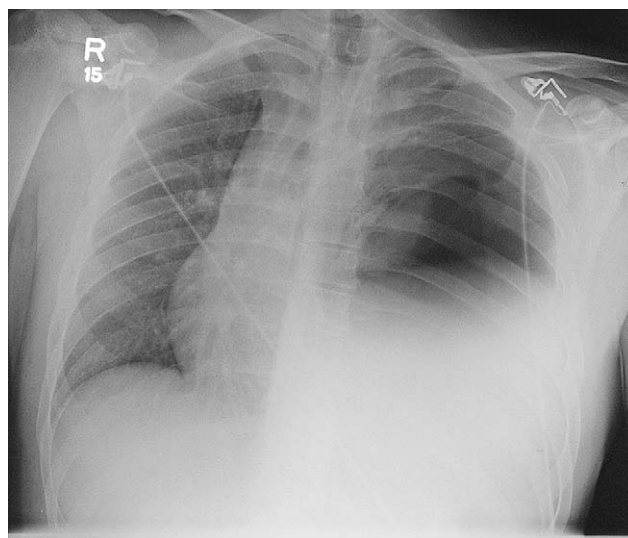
Chest radiograph showing the herniation of the stomach within the left pleural cavity. Please do not confuse with pneumothorax. The air space shadow in this CXR has rounded margins.
